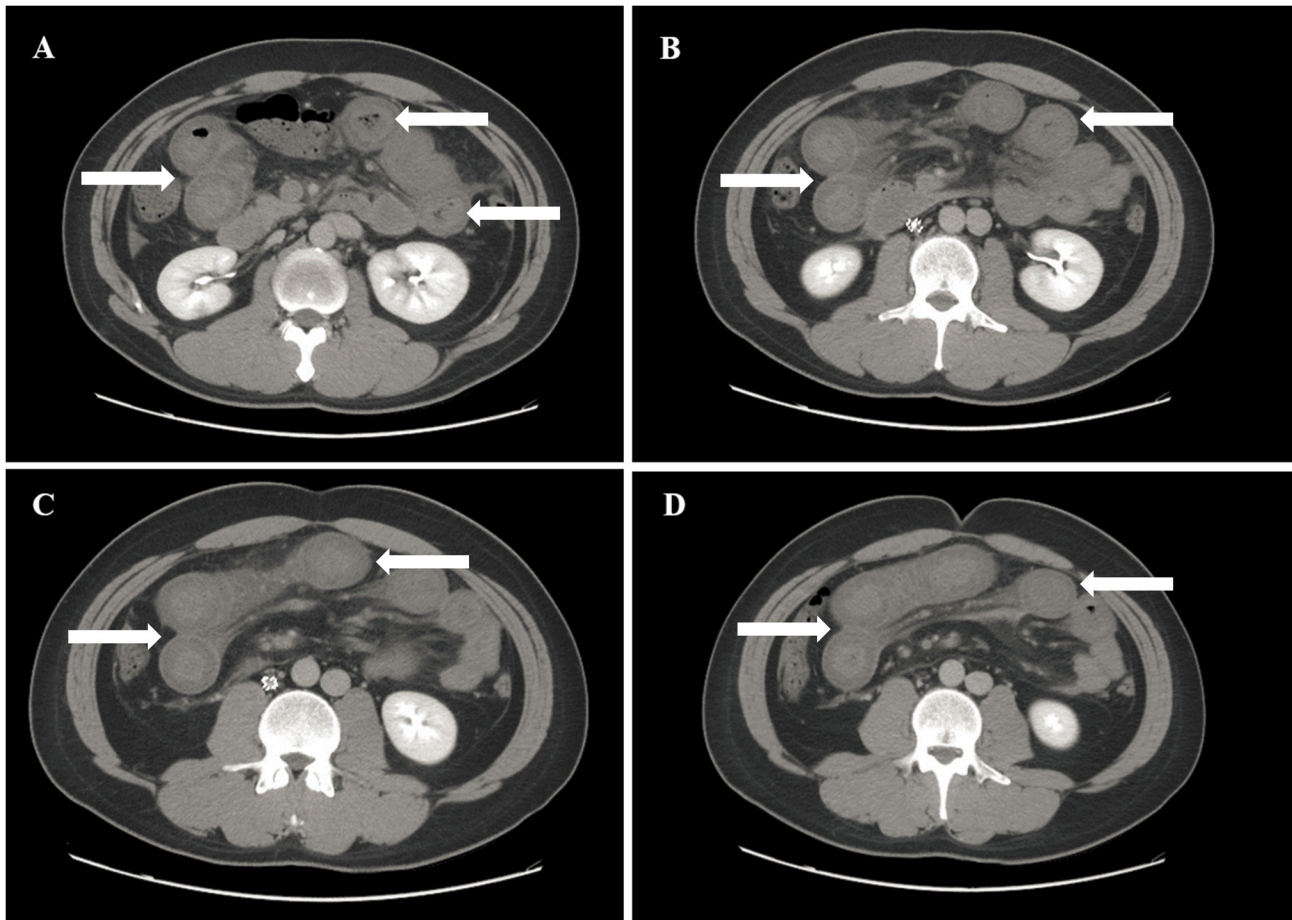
Consecutive axial contrast-enhanced abdominal CT scans (A-D), showing extensive dilation of the small intestine in the upper abdomen, with thickened intestinal walls (arrows indicate dilated small intestinal loops with thickened walls).
